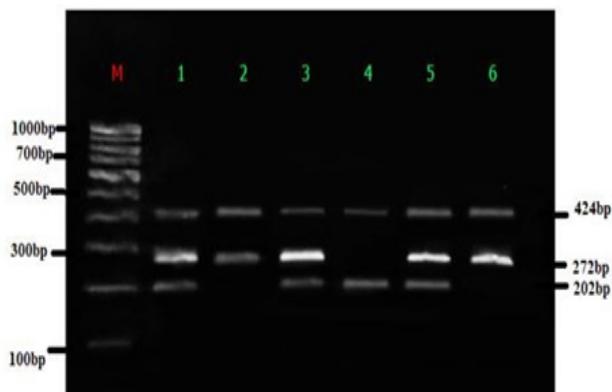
T-ARMS PCR Analysis of TCF7L2 gene. (M)- 100 bp Molecular marker; Lane1, 3, 5 (CT-424 bp, 202 bp, 272bp); Lane 2,5 (TT-424bp, 272 bp); Lane 4 (AA-424 bp, 202bp).
